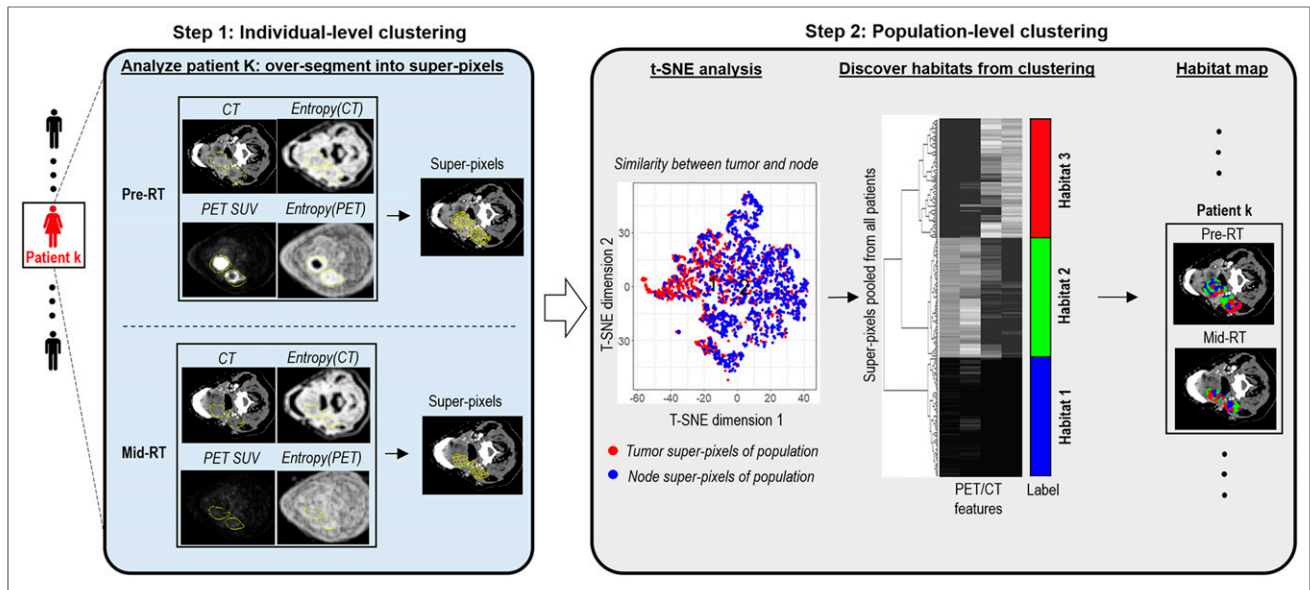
Proposed habitat discovery framework. Method consists of 2-stage clustering process: individual-level clustering based on CT number, PET SUV, and their local entropy maps, followed by population-level consensus clustering. pre-RT = pretreatment of radiation therapy; mid-RT = midtreatment of radiation therapy; t-SNE = t-distributed stochastic neighbor embedding.
